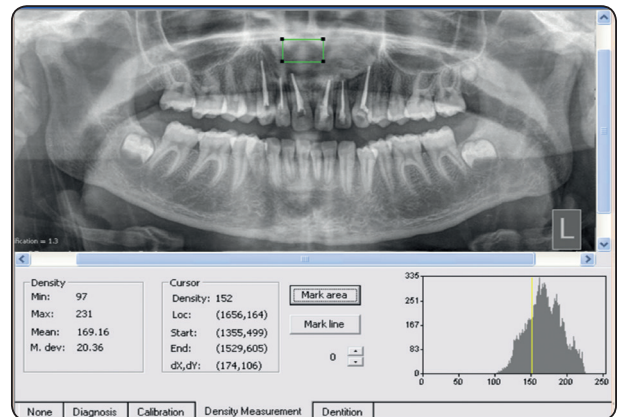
Photograph showing the screenshot of the bone density measurement from orthopantomogram using Digora software.
